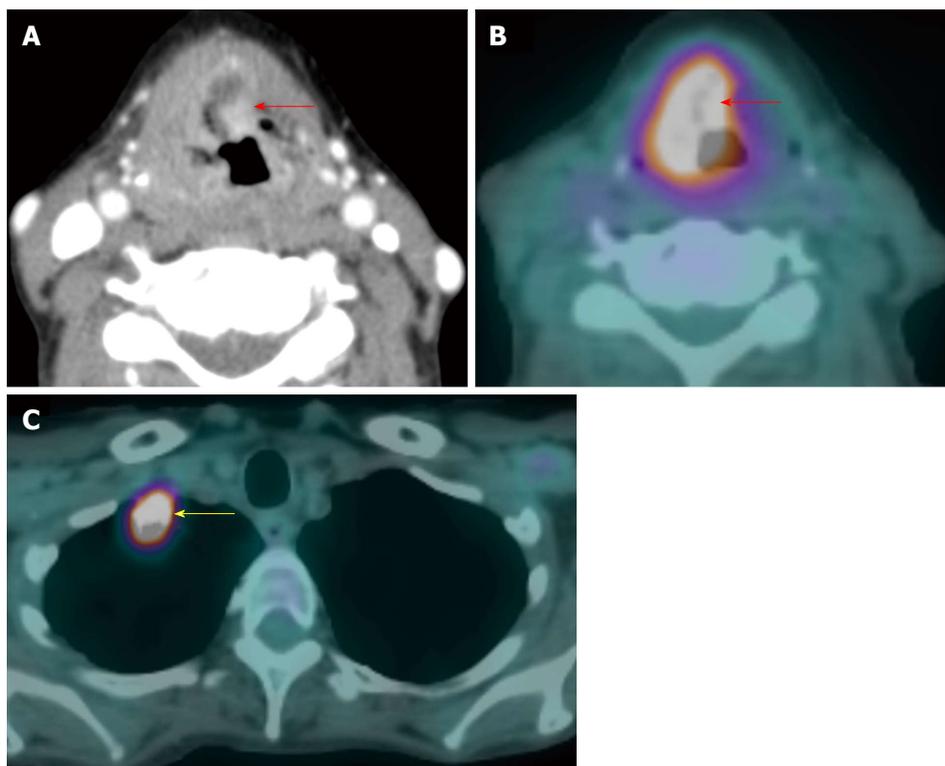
Synchronous second primary malignancy in the lung. A T4a supraglottic squamous cell carcinoma (red arrows) with extralaryngeal invasion is well demonstrated on computed tomography (CT) (A) and positron emission tomography/CT (B). There is a 3-cm hypermetabolic second primary squamous cell carcinoma (yellow arrow) in the right lung apex, discovered at the same time in this patient who had an extensive smoking and drinking history. The rest of the exam is unremarkable.
